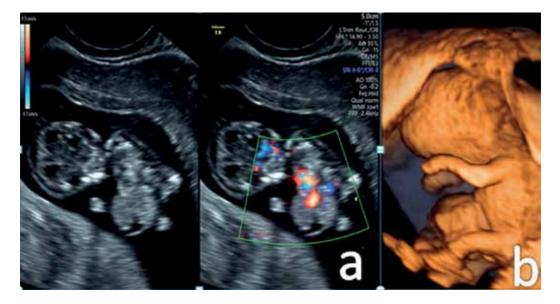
Ultrasound image of a BSS diagnosed in the first trimester: a. Gray scale and color image of the fetus with BSS; b. 3D image of the fetus with BSS.
